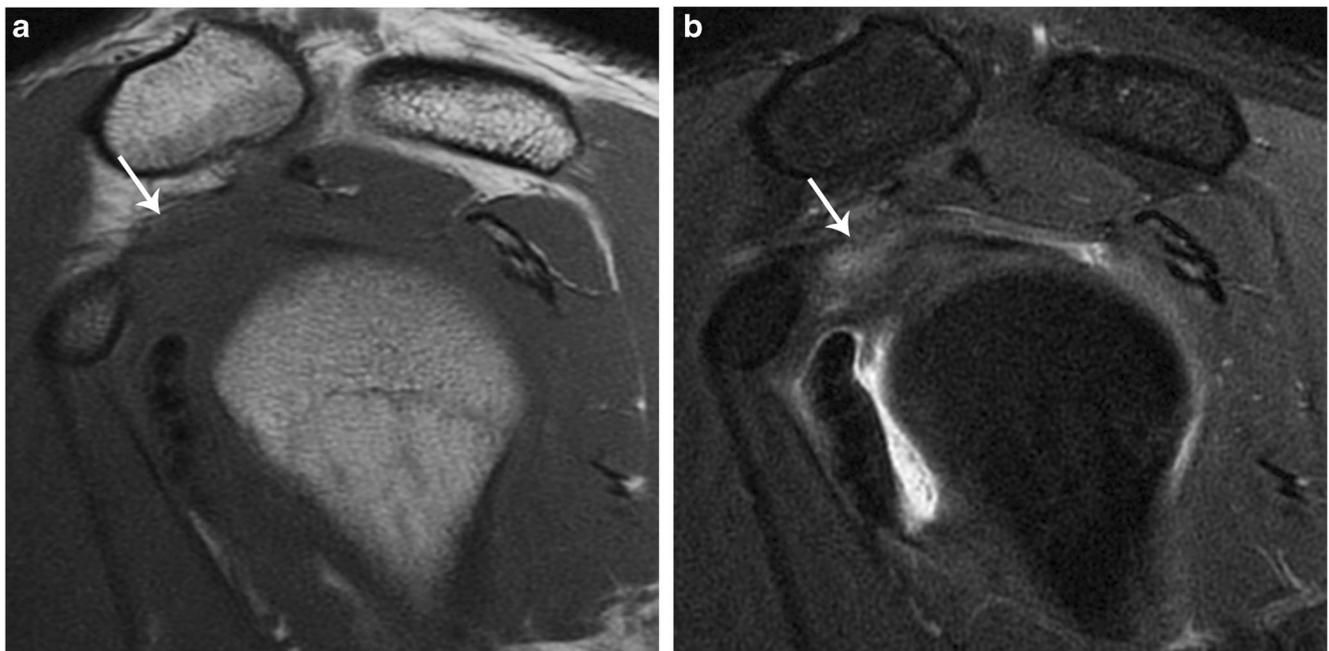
A 33-year-old man with right shoulder pain and a limited range of motion. a Coronal oblique T1 and b T2 FS MR images demonstrate effacement of the subcoracoid fat triangle with intermediate signal intensity (arrows), consistent with adhesive capsulitis
